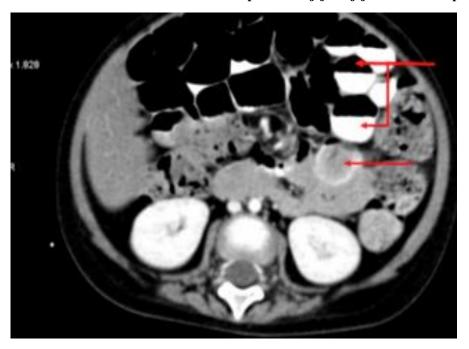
Abdominal CT axial view shows intussusception with proximal bowel dilatation and air fluid level.
